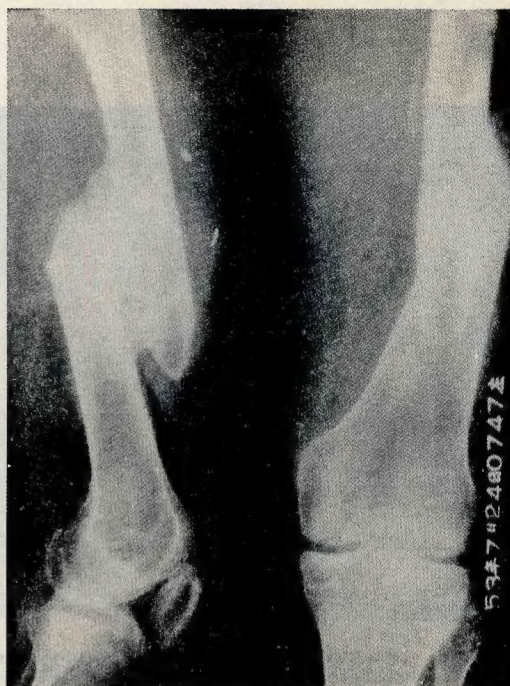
(Record No. 188, I.S.N. 730725) Roentgenogram showing malunion of compound fracture of femur resulting from lack of proper reduction.
